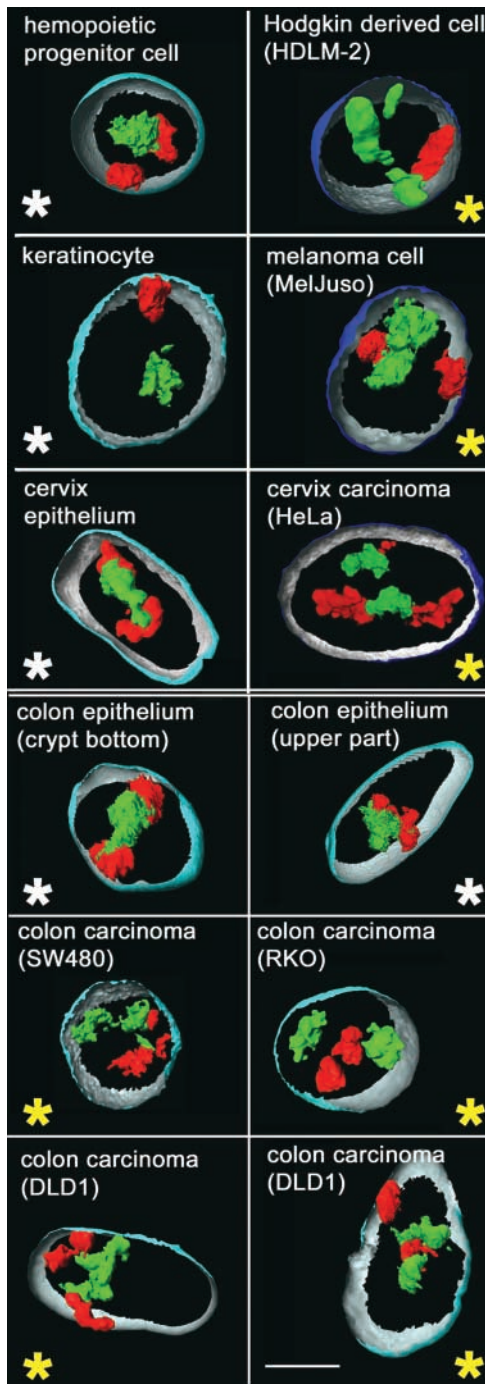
Visualization of CTs #18 (red) and CTs #19 (green) in 3D reconstructions of selected cell types. Part of the nuclear border is indicated by reconstruction of the counterstain periphery (outside, blue; inside, silver-gray). Note that in nuclei of normal cells (panels marked by a white asterisk), the CTs #19 are closely attached in the nuclear interior, whereas CTs #18 are found at the nuclear periphery, either side-by-side or at remote sites. In tumor cell nuclei (panels marked by a yellow asterisk), this radial distribution difference is often less apparent; note, for example, a peripheral CT #19 in a Hodgkin-derived cell nucleus (top right) or the internal position of a CT #18, which is located between two CTs #19 in one of the two DLD1 nuclei (bottom right panel) displayed. Bar, 5 μ m.
